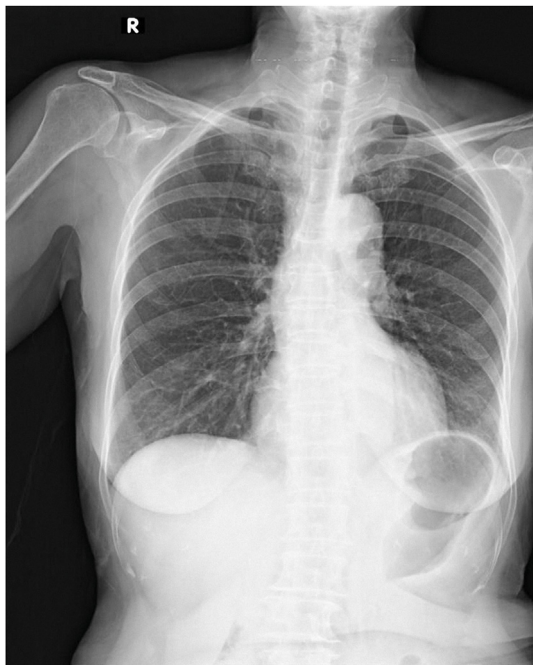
Preoperative chest X-ray did not show any abnormal finding.
